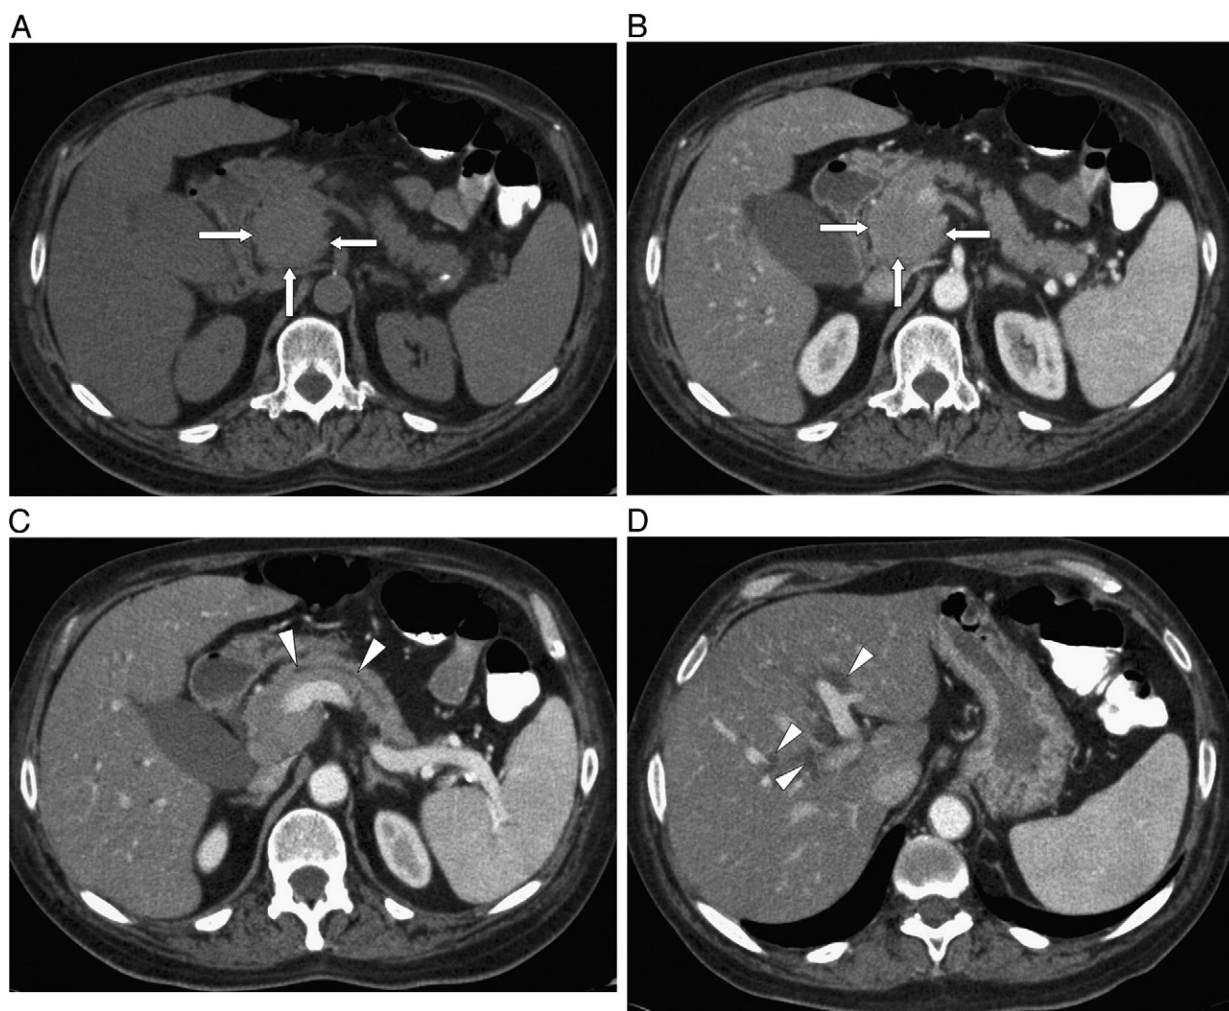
Transverse CT scan images at the level of the pancreatic head without (A) and with intravenous contrast (B) show homogeneous isodense solid mass in the pancreatic head (arrows) with contrast enhancement similar to the rest of the pancreas. Slightly higher contrast images (C and D) show mild pancreatic ductal dilatation (arrowheads in C) and biliary ductal dilatation (arrowheads in D), respectively.
